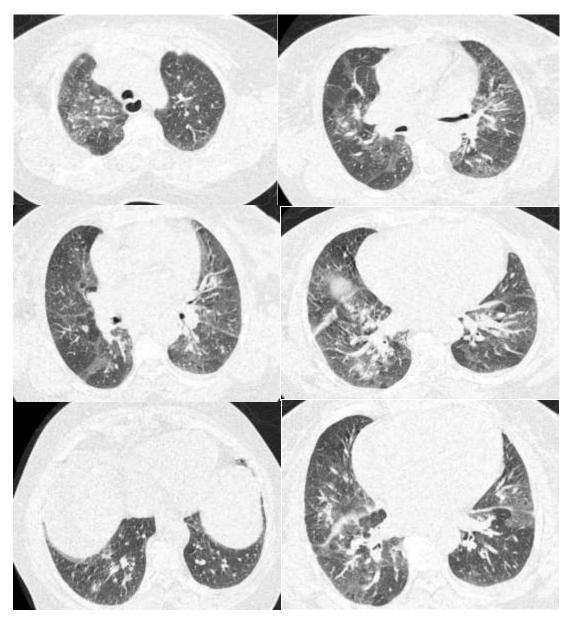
Multiple axial cuts of high-resolution CT chest of female patient 55 years old showing Bilateral diffuse mosaic attenuation pattern with areas of GG attenuation, associated with bilateral multiple variables sized pulmonary nodules mainly located perilymphatic, as well as bilateral lower lobar atelectatic bands and right lower lobe coalescent nodules as well.
